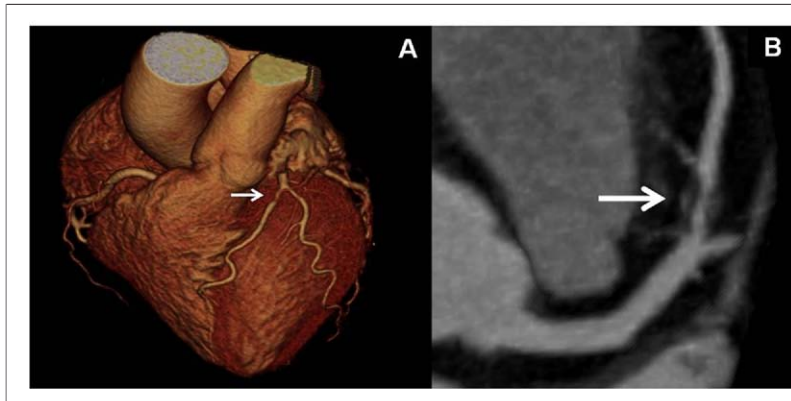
Coronary CT Angiography Findings
